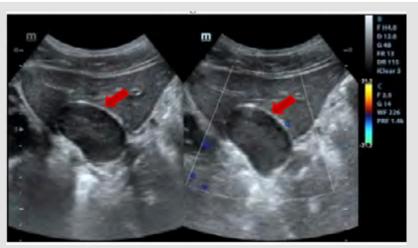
The lesion was observed through two-dimensional ultrasound imaging and color Doppler flow imaging. Red arrow:
